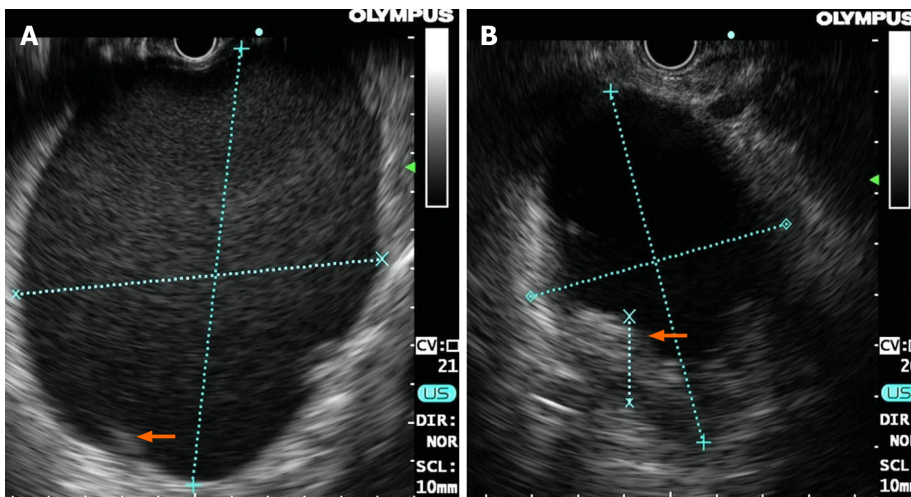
Endoscopic ultrasound images of the lesion in each patient. A: The size and high-density shadows (arrow) of the lesion in the female on endoscopic ultrasound (EUS); B: The size and high-density shadows (arrow) of the lesion in the male on EUS.
